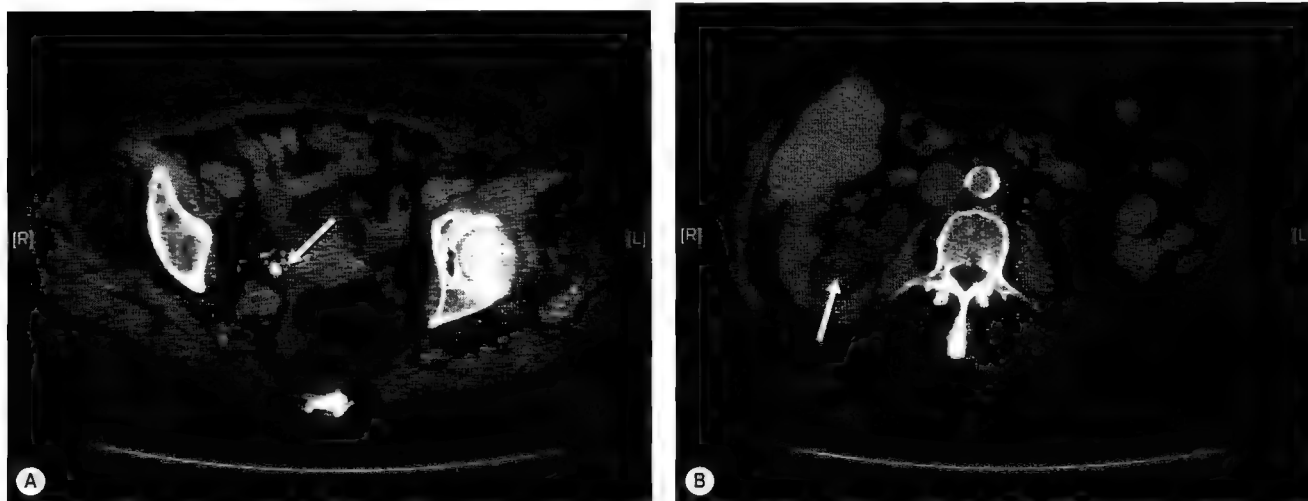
A, Pelvic CT scan showing stone fragment in lower right ureter (arrow). B, Abdominal CT scan showing dilated right renal pelvis (arrow) above an obstructing calculus.
